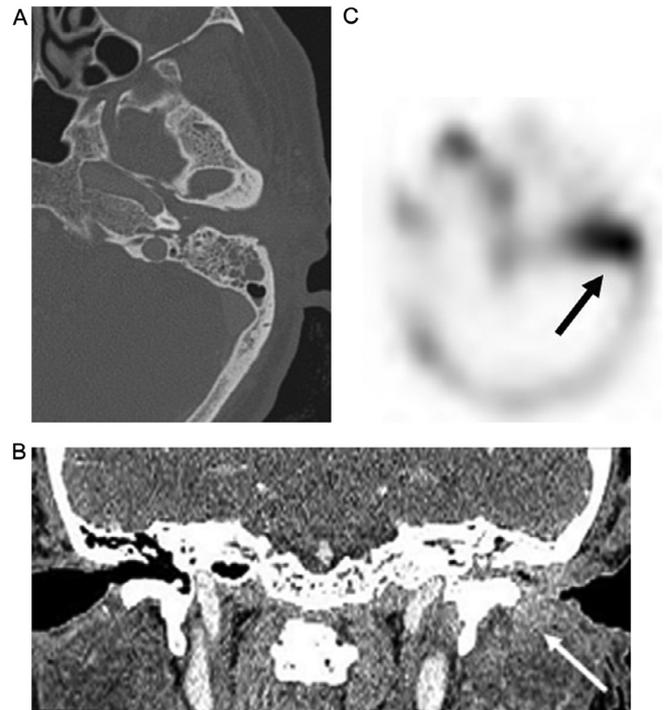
71f h/o AML with pseudomonas infection. Axial CT image (A) shows soft tissue in the EAC without osseous erosion. Coronal postcontrast image (B) shows extension of infection through the floor of the EAC (arrow). Tc-99 m MDP bone scan with SPECT (C) shows increased osseous uptake on delayed imaging (arrow).
